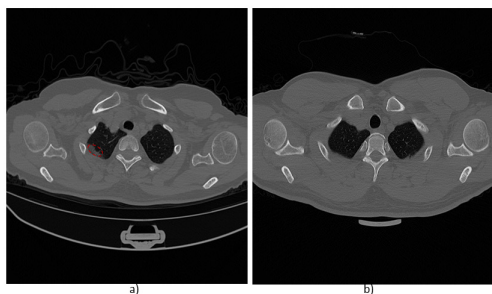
CT images from the apex region of the upper lobes of the lungs. a) CT slice that presents consolidation in the right lung (enclosed with a red segmented red oval), b) CT slice that does not show abnormal signs.
